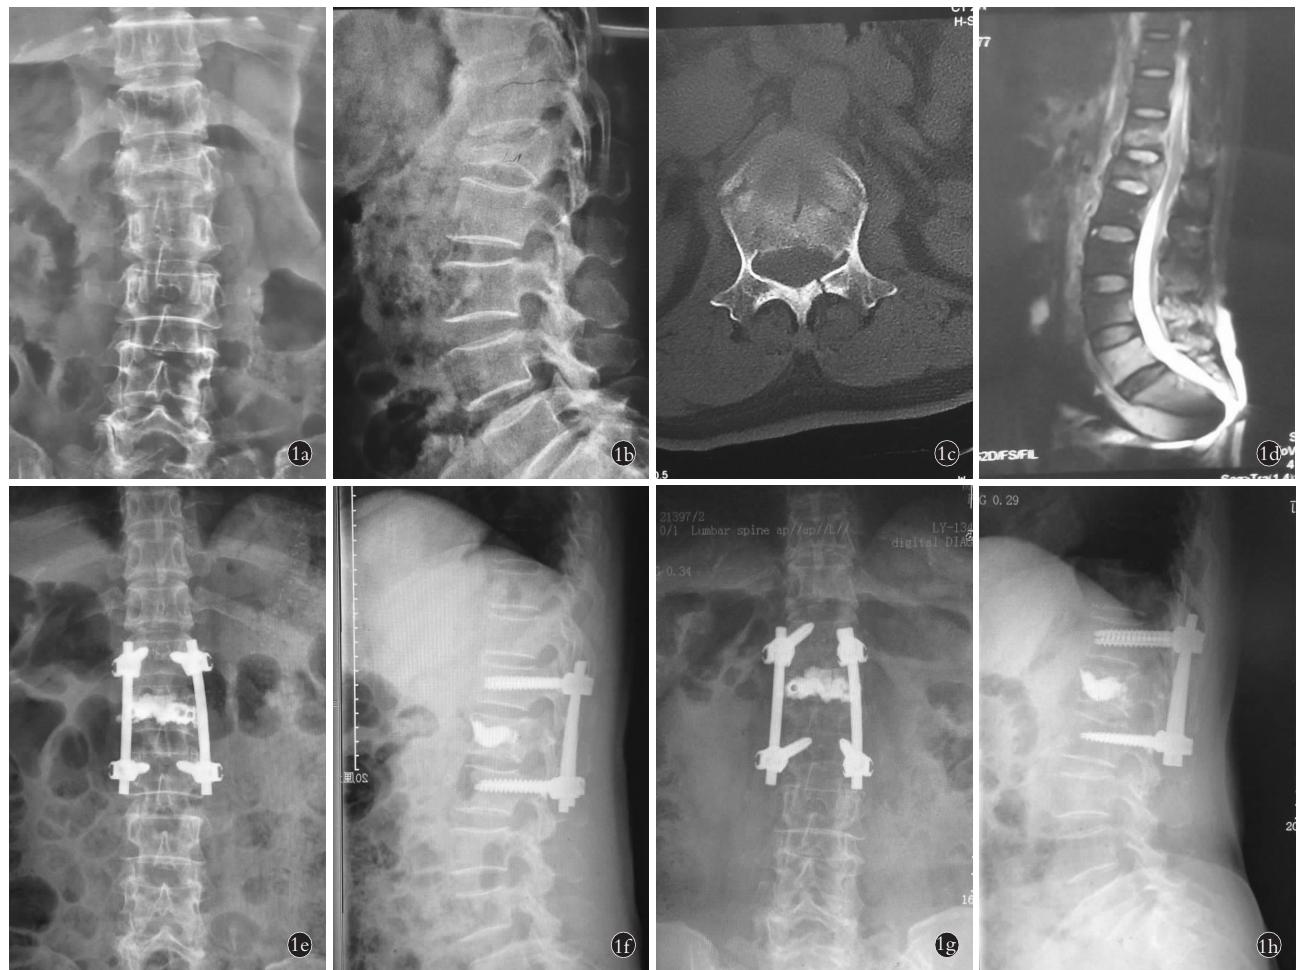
患者,女,57岁,L₁骨质疏松性爆裂骨折(AO 分型为 A4 型),麻醉下行短节段椎弓根螺钉固定联合伤椎椎体成形术 1a,1b. 术前腰椎正侧位 X 线示 L₁爆裂性骨折,骨质疏松,上下终板损伤 1c. 术前横断位 CT 示 L₁后壁骨折块侵入椎管,椎板断裂 1d. 术前矢状面 T2WI MRI 所示 L₁椎体前中柱高信号 1e,1f. 术后 1 周正侧位 X 线示骨折复位满意,骨水泥、内固定位置良好 1g,1h. 术后 1 年正侧位 X 线示伤椎高度无明显丢失,内固定无松动
